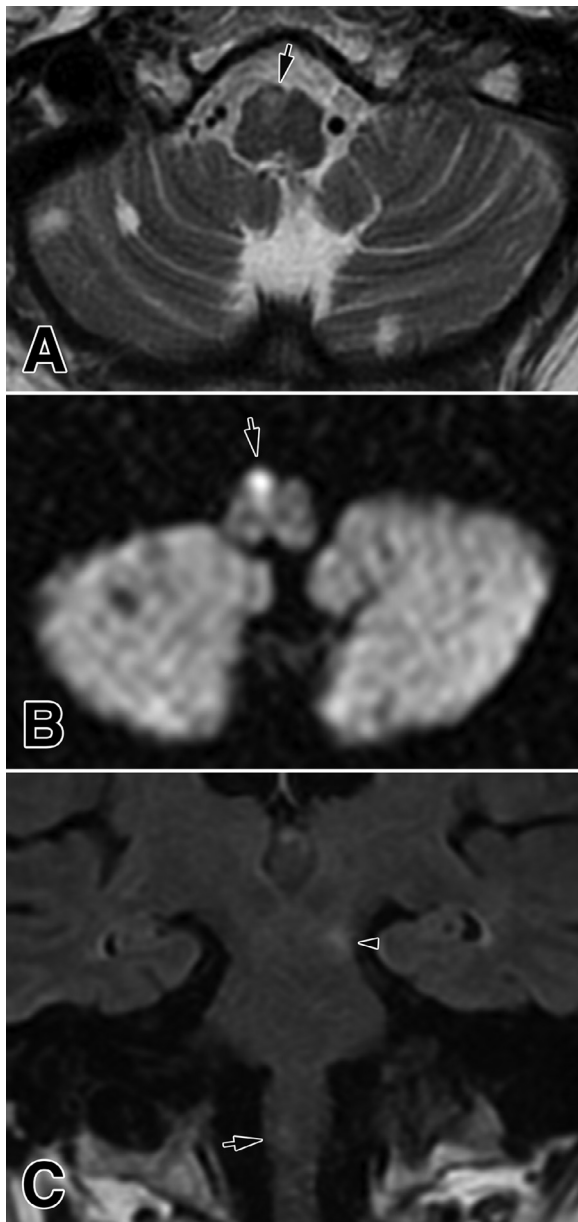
A right incomplete medial infarction (arrows) of the middle and upper medulla in the axial T2-weighted (A) and DWI image (B), and in a coronal FLAIR image (C). Note a small lacunar ischemia (arrowhead) in the left cerebral peduncle.
